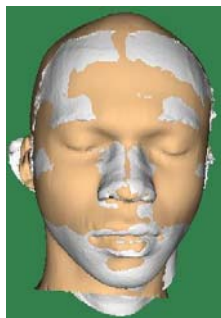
Soft tissue extracted from laser scan (white color) superimposed on soft tissue reconstructed from CT data (off-white)
